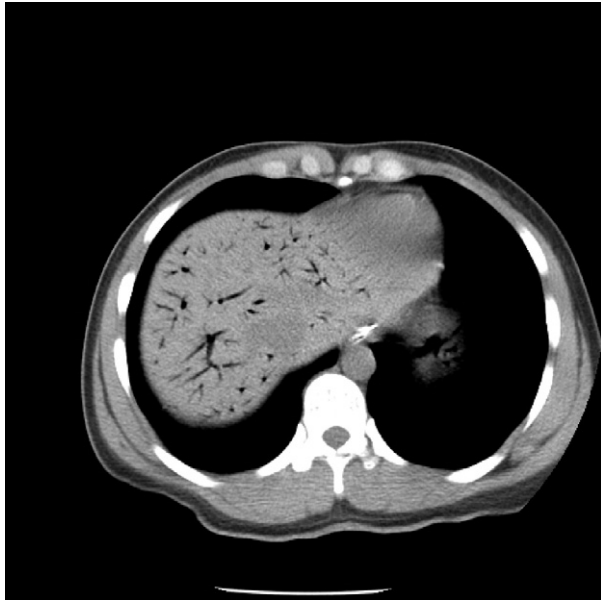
Computed tomography scan shows air in the portal venous system.
